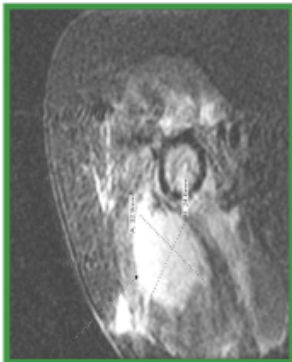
MRI shows a 3.5 cm x 2.5 cm abscess within deltoid muscle
